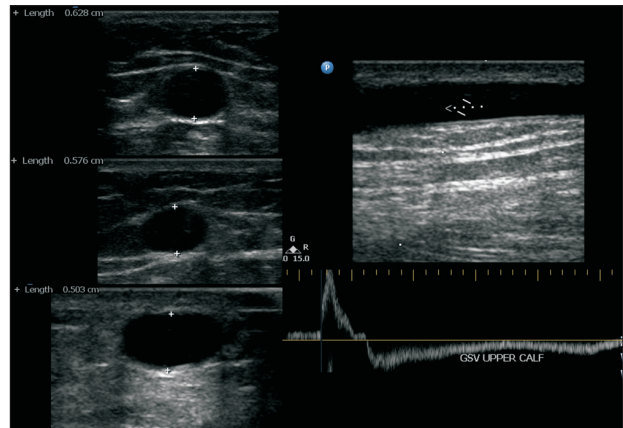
Preoperative duplex ultrasonography for saphenous vein evaluation. The diameter of the left great saphenous vein (GSV) was about 5 to 7 mm, and reflux was noted in the whole length of the GSV.
